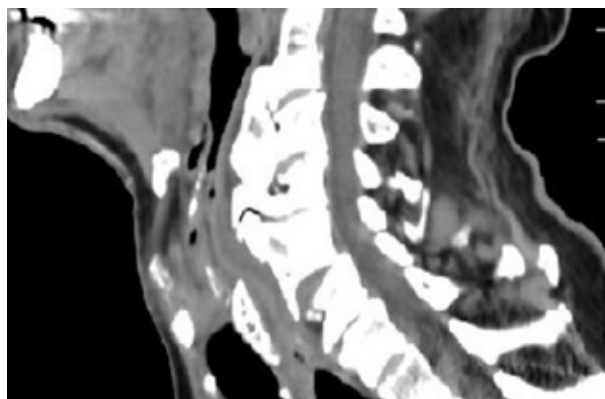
Neck CT scan performed on admission, showing the reduction of air space at the laryngeal level.
